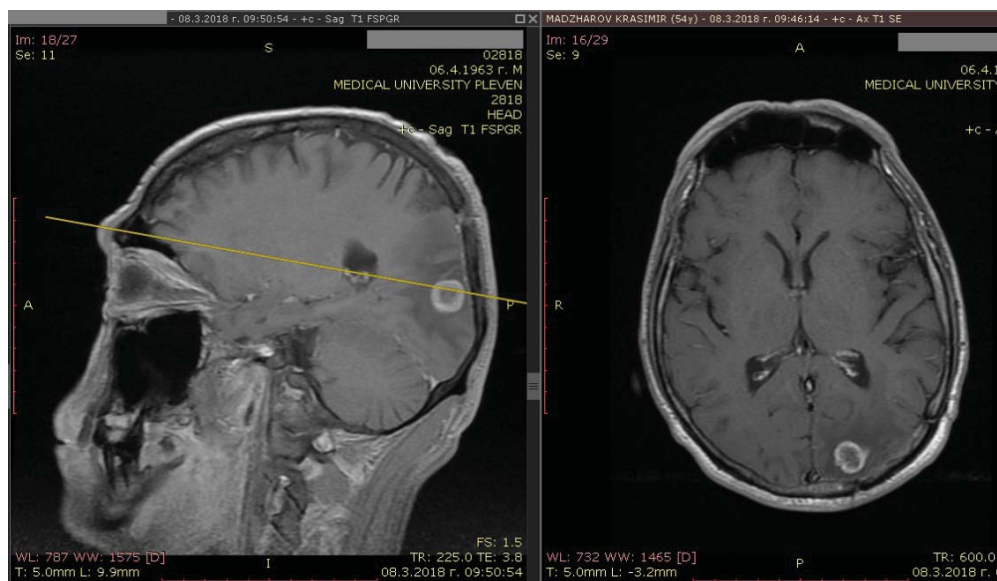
MRI scan/topogram showing occipital meta
